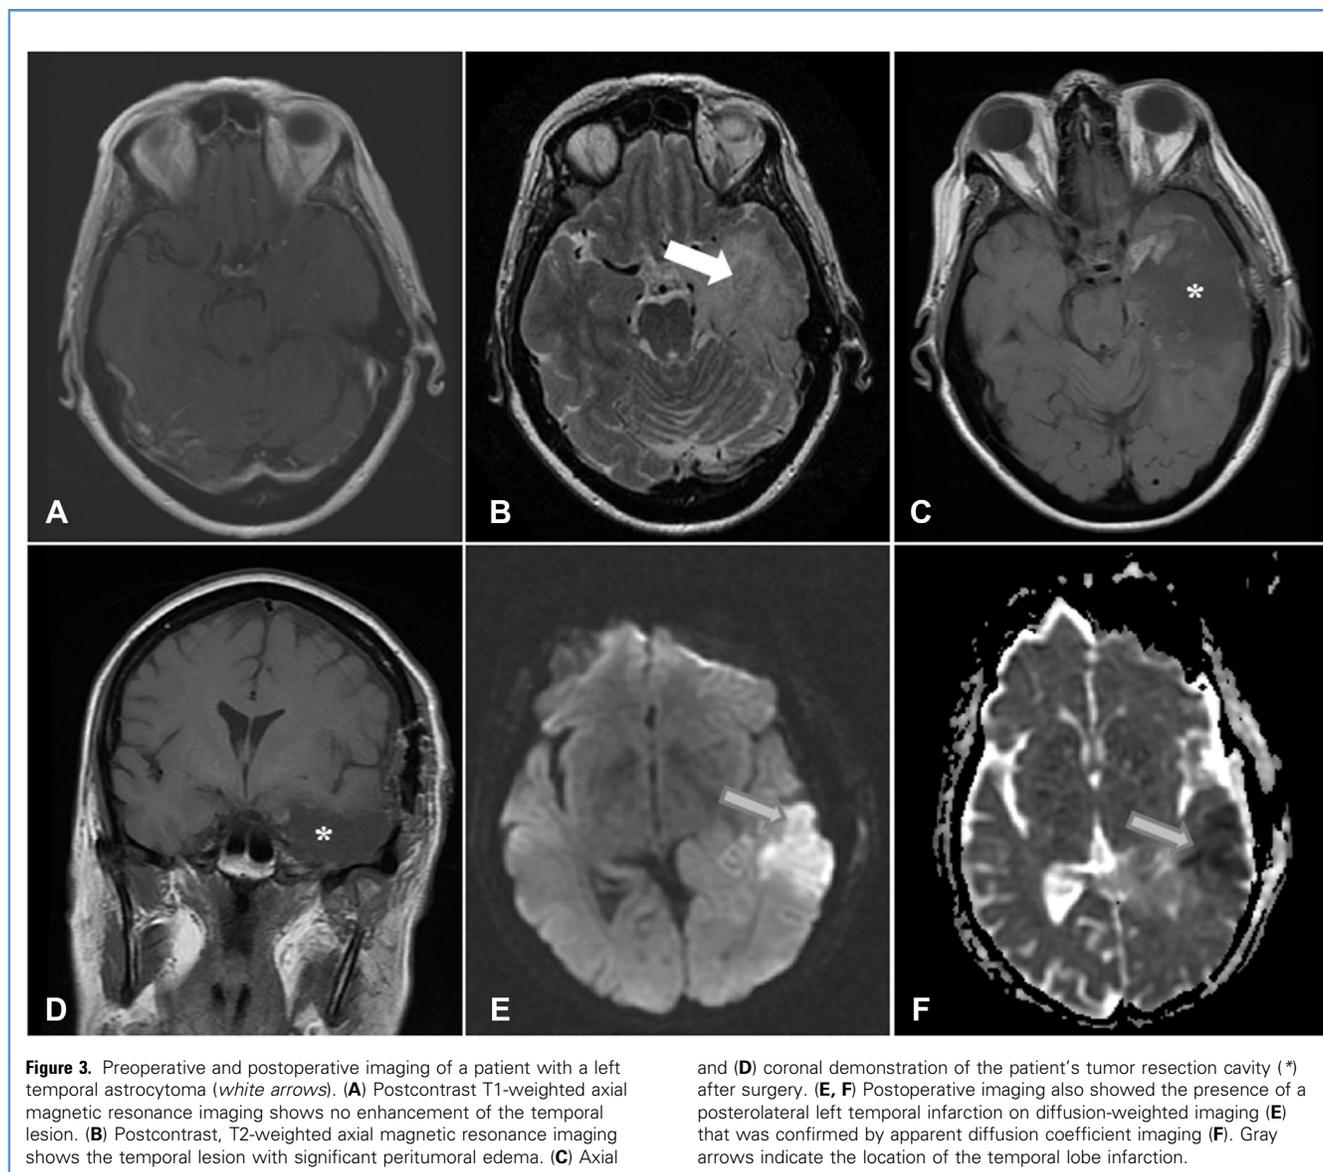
Preoperative and postoperative imaging of a patient with a left temporal astrocytoma (*white arrows*). (A) Postcontrast T1-weighted axial magnetic resonance imaging shows no enhancement of the temporal lesion. (B) Postcontrast, T2-weighted axial magnetic resonance imaging shows the temporal lesion with significant peritumoral edema. (C) Axial
